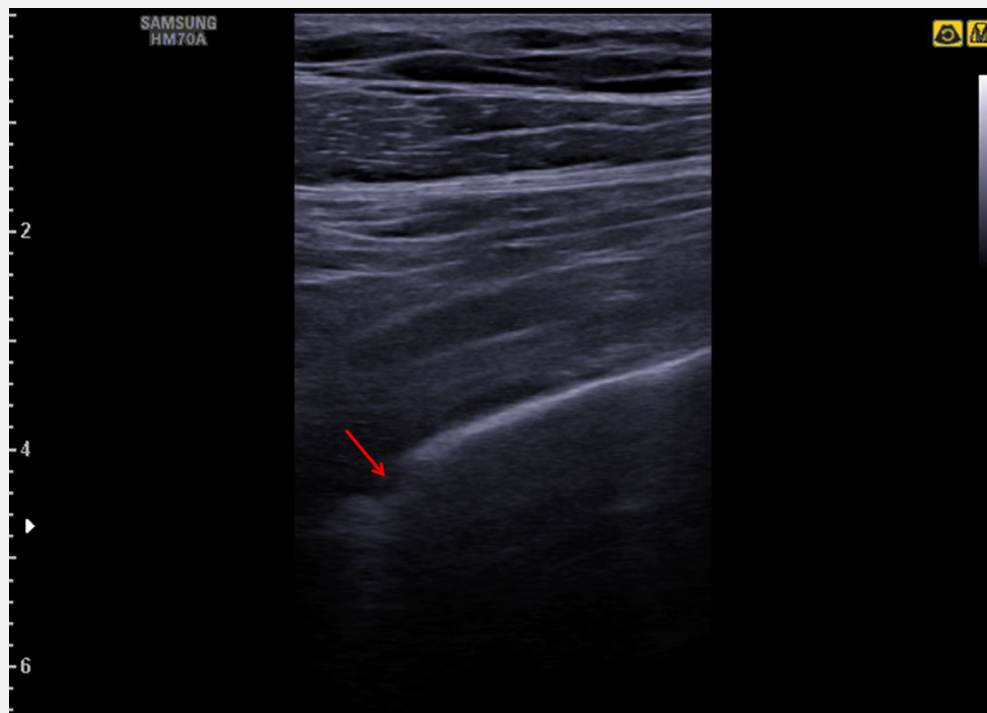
Lung ultrasound using the Samsung HM70A. Thickening and irregularity of the pleural line (red arrow) was demonstrated using a high-frequency linear transducer.
